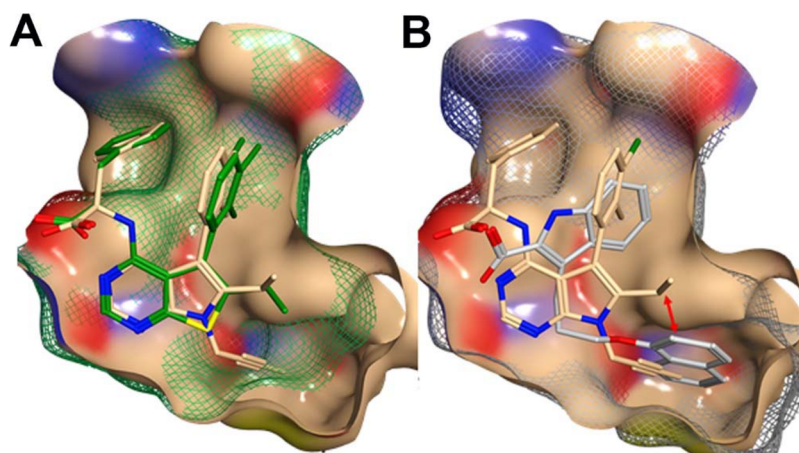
Comparison of the X-ray structures of the complexes of Mcl-1 and its inhibitors. (A) 7b (beige; PDB: 7NB7) and 1 (green). (B) 7b (beige) and literature structure 6B4L (gray). The protein surfaces are colored according to the bound ligands, respectively. Proximity of 7b position-6 ethyl to 6B4L naphthyl is indicated by a red arrow.
